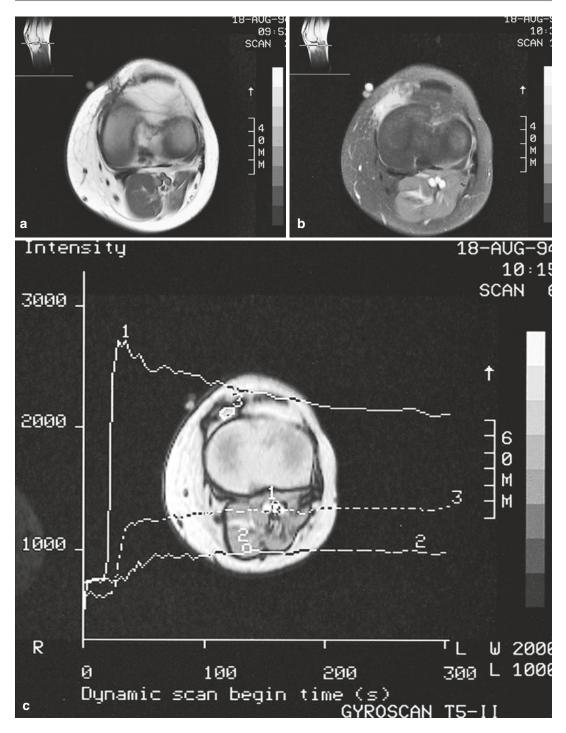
Recurrent synovial sarcoma. (a) Axial spinecho T1-weighted MR image. (b) Axial, fat-suppressed, spin-echo T1-weighted MR image after gadolinium contrast injection. (c) Signal intensity-versus-time curve calculated on a gradient-recalled echo T1-weighted MR image during gadolinium contrast injection. Synovial sarcoma quite frequently recurs after surgical excision. In this case, a small hypointense lesion located deep in the scar tissue can be noted on the T1-weighted image (a). After gadolinium injection, clear enhancement of this region can be noted on the fat-suppressed images (b). Dynamic imaging during bolus contrast injection (c) demonstrates the higher and more rapid uptake of contrast medium by this tissue (3) than by normal muscle (2). Repeat surgery disclosed recurrent tumor
